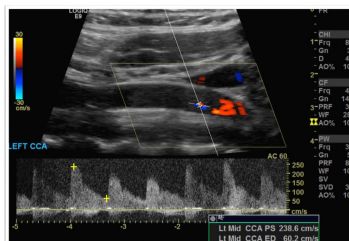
Carotid Doppler demonstrating free floating CCA thrombus and high grade occlusion.
